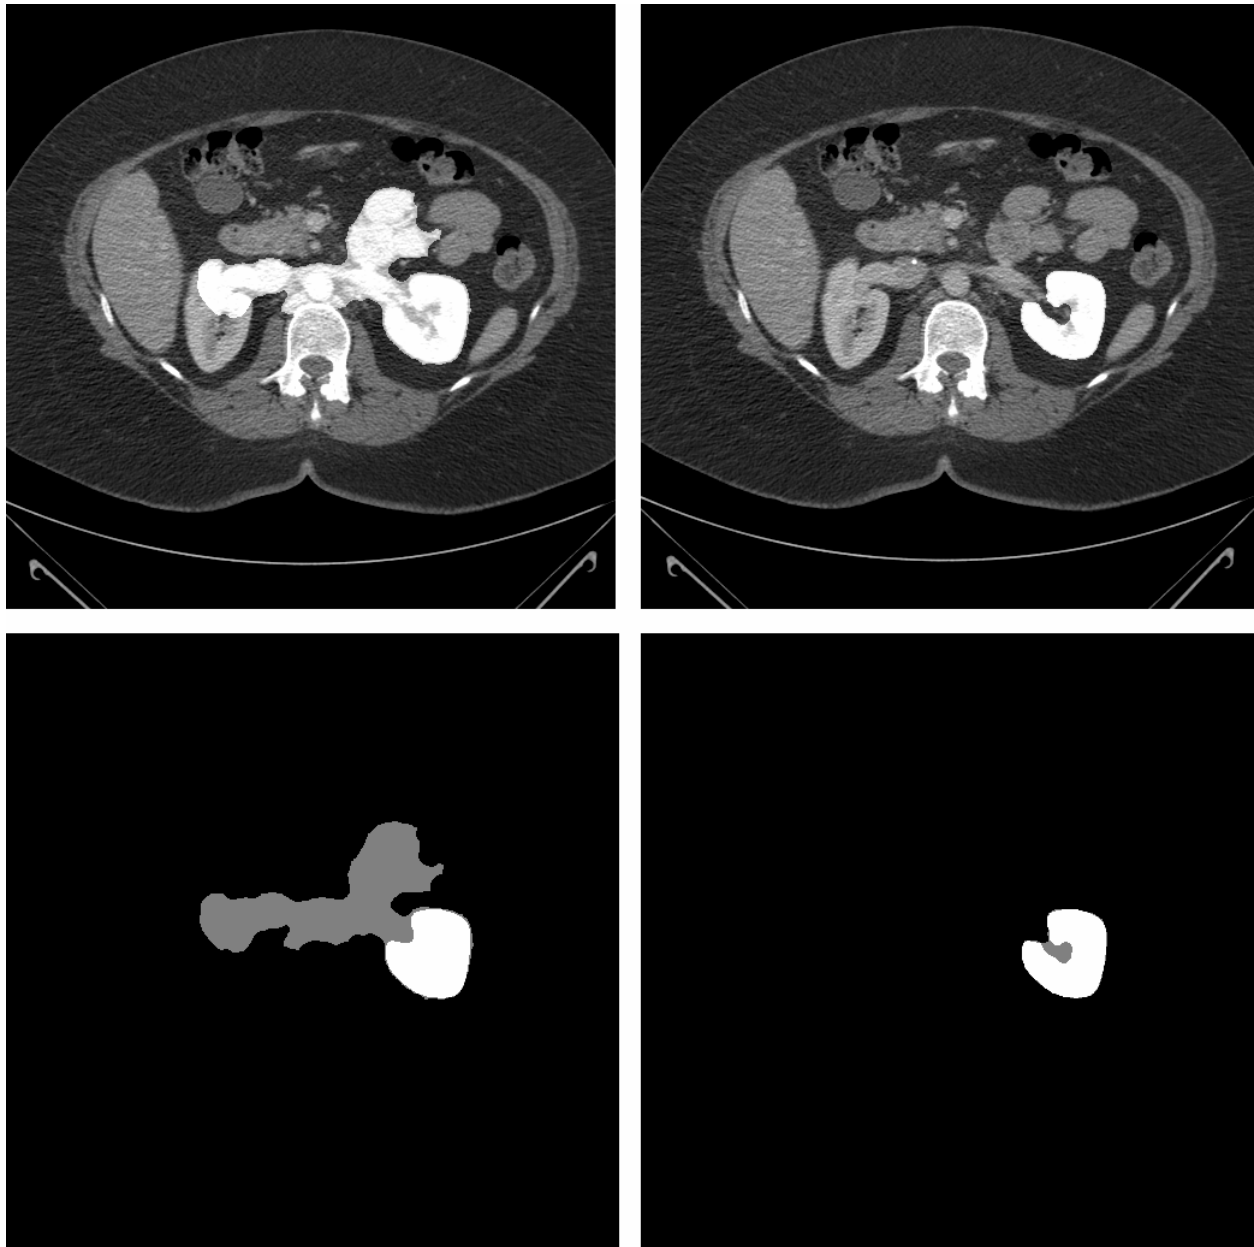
Semi-automatic algorithm corrected by parameter change. Left column: ThresholdLevelSet method using high propagation scaling causes an oversegmentation due to easily followed vasculature on CT. Lower panel shows the extent of the oversegmentation overlaid onto the handsegmentation. The white area represents pixels segmented by both the handsegmenter and the algorithm. Right column: The same method's results using lower propagation scaling, automatically implemented upon detection of the preceding failure. Lower panel again shows autosegmentation overlaid onto handsegmentation, with the white area representing pixels chosen by both methods. The autosegmentation undersegments the calyceal area, leaving the gray defect.
